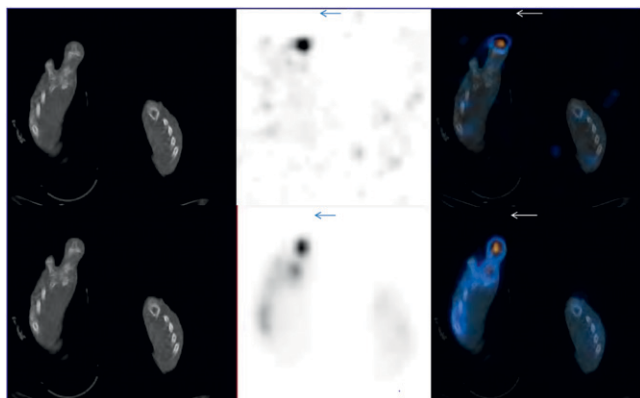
Right large toe distal phalanx osteomyelitis in a diabetic patient. Left: CT. Middle: White blood cell SPECT transverse (top). Right: Fused SPECT/CT shows uptake in distal digit of first toe.
